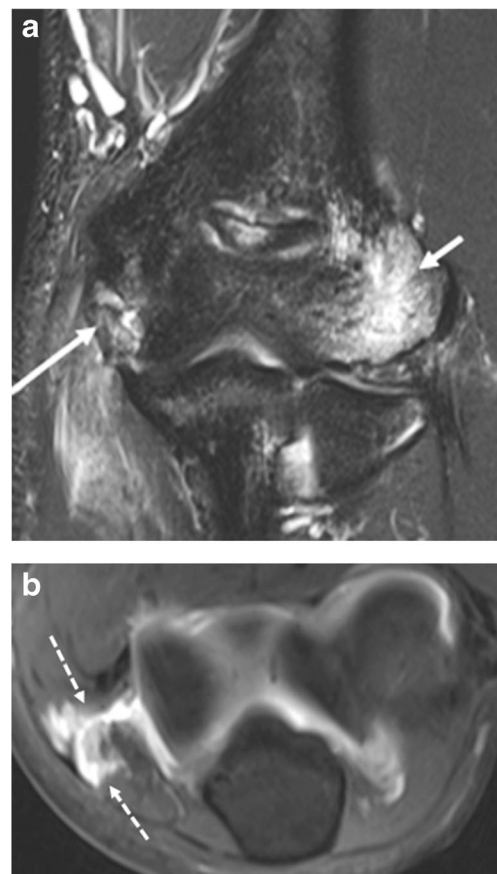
Unstable osteochondral lesion of the capitellum in a 17-year-old girl, a gymnast with medial elbow pain. a, b Coronal T2-weighted fat-suppressed (a) and sagittal T1-weighted fat-suppressed (b) MR images of the elbow after intraarticular injection of gadolinium contrast agent show an osteochondral lesion within the capitellum. a Marrow edema is seen surrounding the lesion (*arrow*). b Gadolinium contrast agent delaminates deep to the osteochondral fragment, consistent with an unstable lesion
